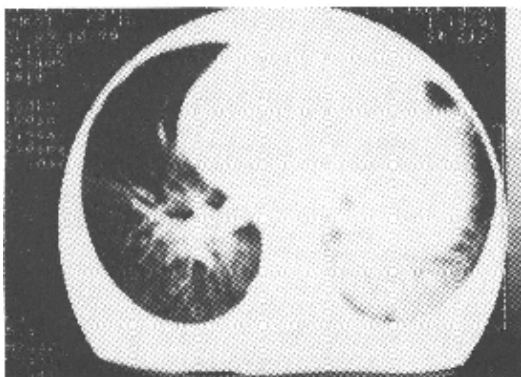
Chest CT scan of the patient showing a lesion in the left upper lobe of the lung
